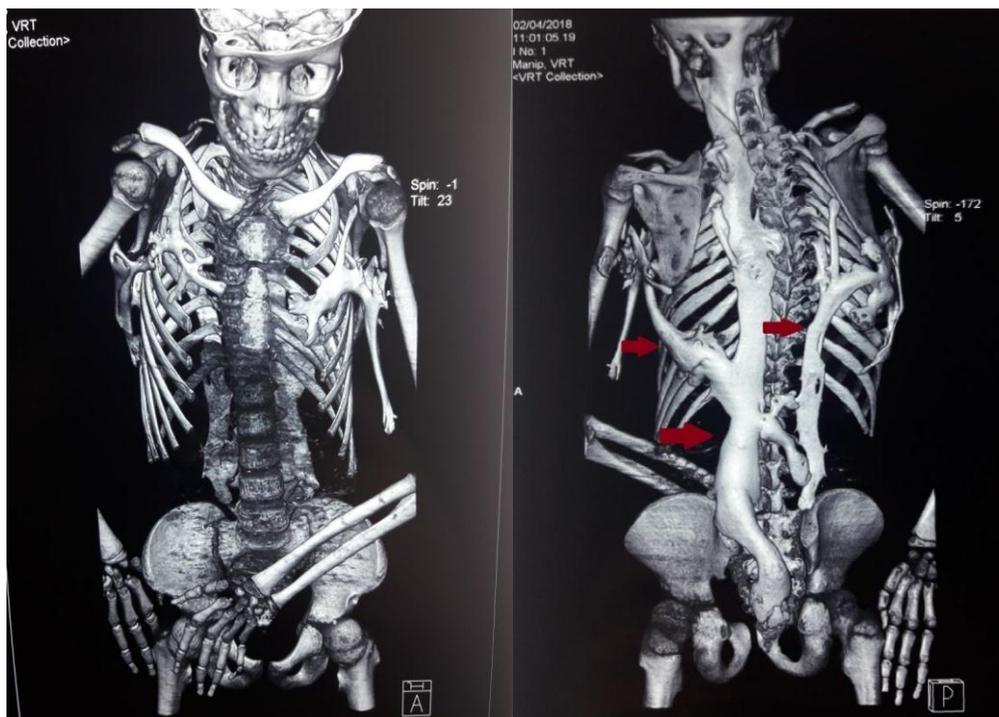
Ectopic ossification on CT scan.
